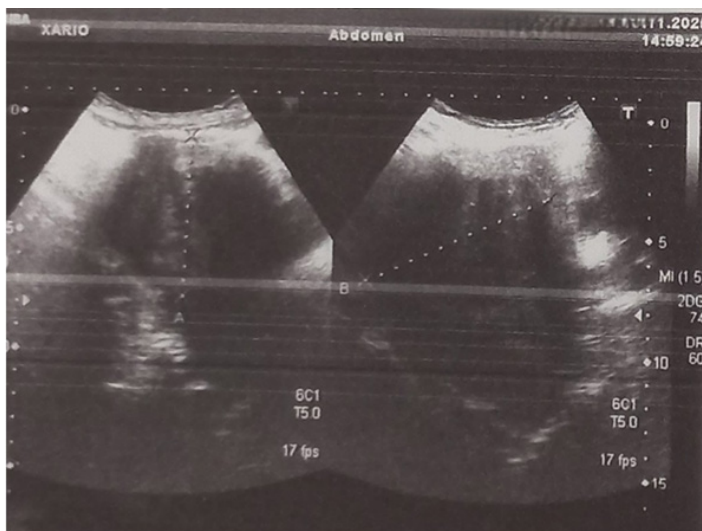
Appearance of the pelvic mass by ultrasound.
